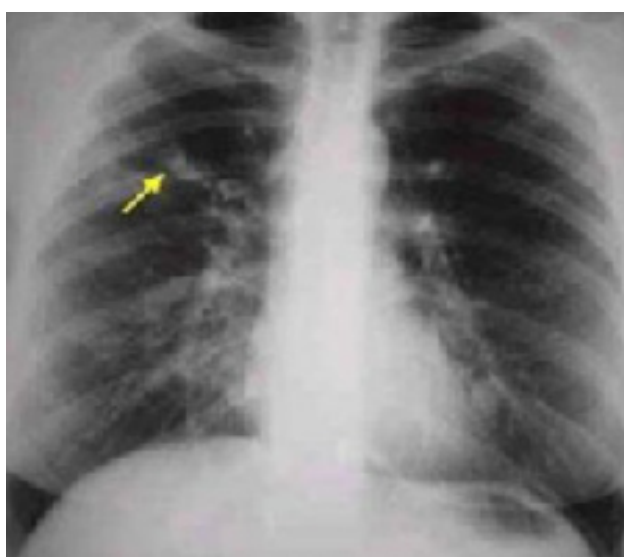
Chest xray showing finger in glove shadow (arrow) and modular opacities in right middle third in ABPA
